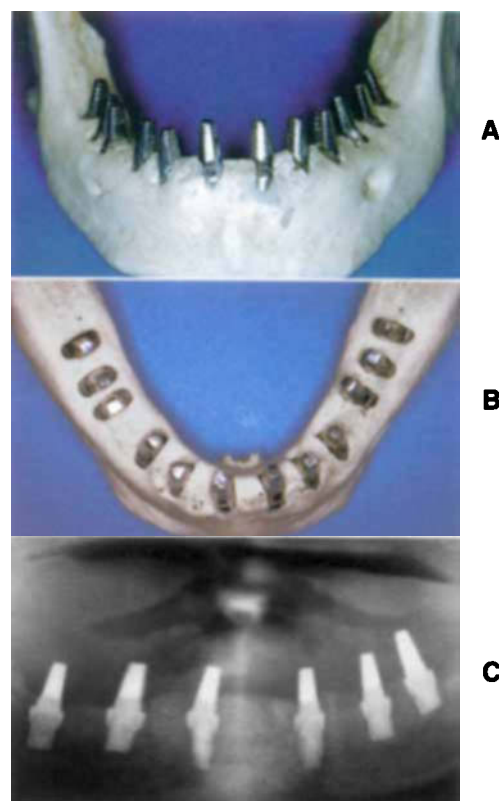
■ Anterior (A), occlusal (B), and radiographic (C) views of serial placement of combination plate/blade and root form implants in mandible.
